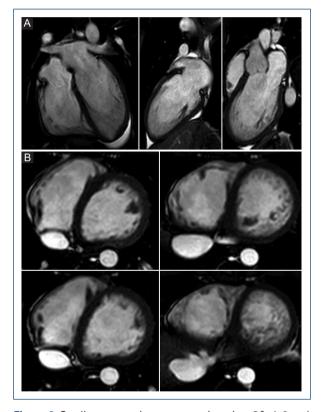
Cardiac magnetic resonance imaging. 2A: 4, 2 and 3 chamber axis; 2B: short axis of the left ventricular (LV) from basal to apical segments) showing a non-compactation pattern in the inferior, lateral and apical walls of the LV.
